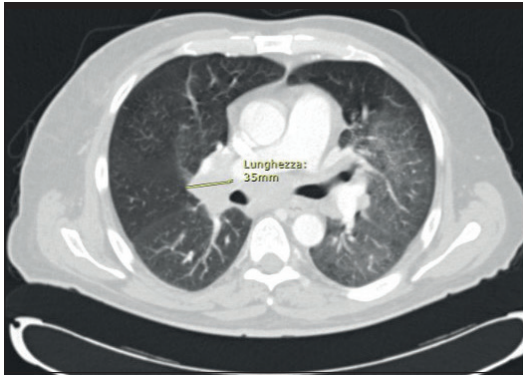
Chest computed tomography (CT) scan (Nov. 2023): ground-glass thickening of the left lung and lymphadenopathy in the hilar site bilaterally (maximum diameter 3.5 cm).
